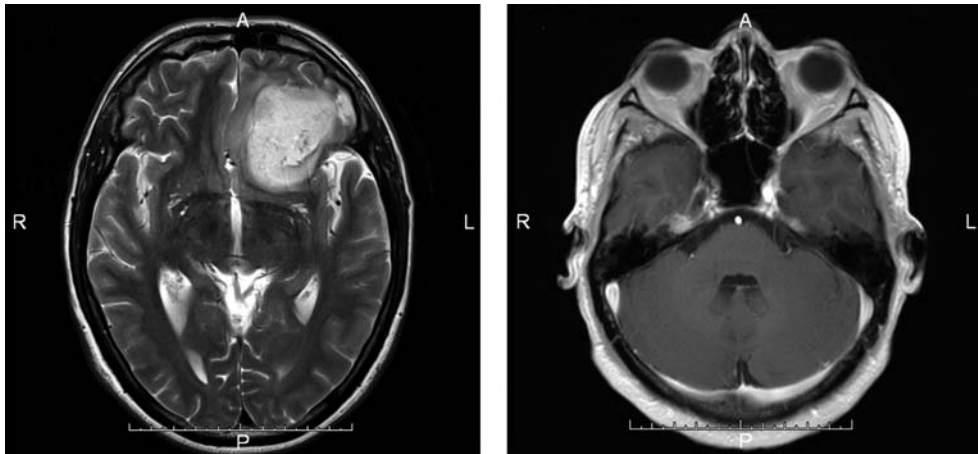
Left: MRI T2 weighted axial image showing the left frontal tumor. Right: MRI T1 weighted with gadolinium image showing a normal posterior fossa.
